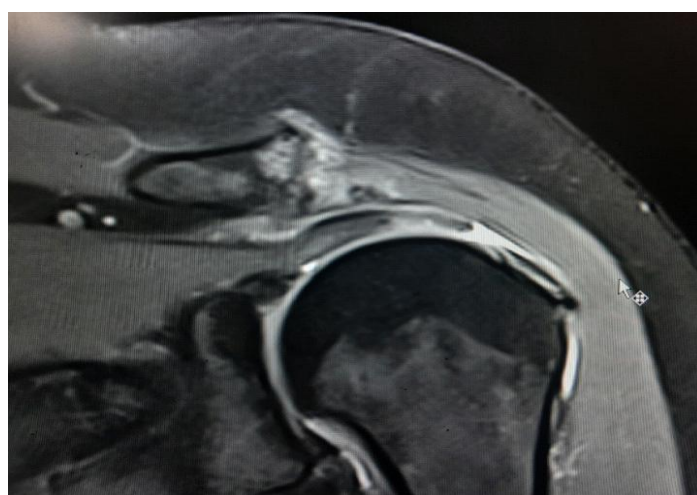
Coronal MRI Shoulder image revealing subchondral edema and irregularities involving acromio-clavicular joint consistent with arthropathy along with complete tear involving Supraspinatus tendon.
